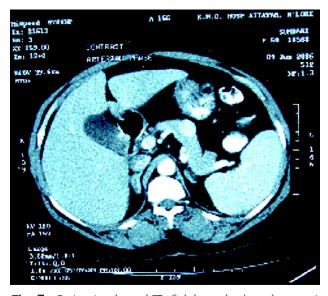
Contrast—enhanced CT of abdomen showing enhancement of the lesion during arterial phase.
